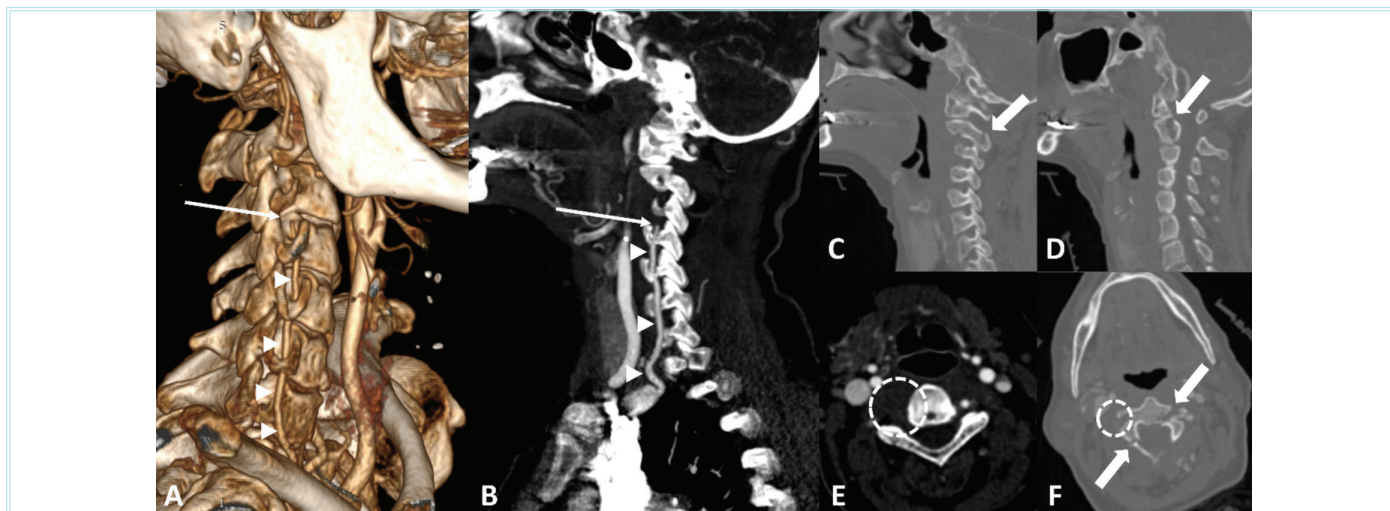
Sixty-five year-old female patient, upper cervical vertebra fracture and concurrent blunt vertebral artery injury. A) Three-dimensional volume rendering of computed tomography (CT) angiography (CTA) and B) 3D MIP image in sagittal view showing a sudden interruption in the right vertebral artery due to injury (thin arrows). C, D) CT sagittal bone reformat images show the extension of C2 vertebra fractures (thick arrows). E-F Axial section image of CTA showing no contrast filling in the right vertebral artery (circle) in subsequent sections after the injury. F) Axial bone reformatting image of CT showing the extension of fractures in C2 vertebra (thick arrows) and absence of contrast filling in the right vertebral artery (circle)
